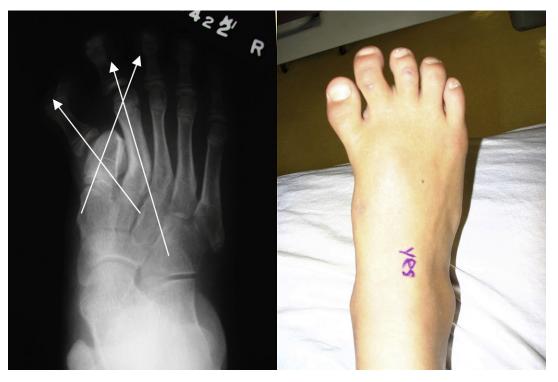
Preoperative radiographic and clinical images demonstrating longitudinal epiphyseal bracket disease.
